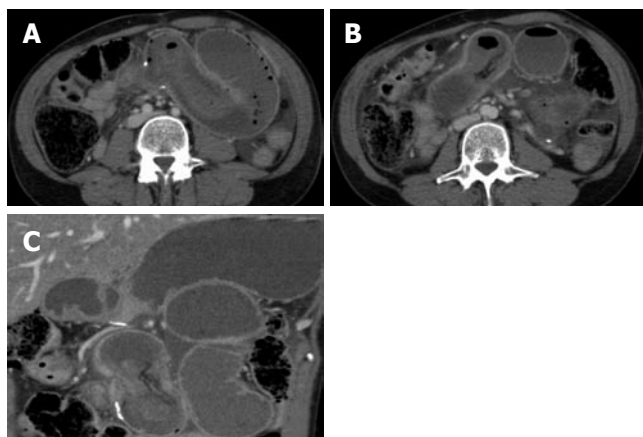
Axial (A and B) and coronal (C) CT images of the abdomen following intravenous contrast administration, which show large dilated loops of small bowel proximal to the intussusception. The intussuscepted bowel entered the more distal jejunum via the jejunal anastomotic site, which is evident due to the presence of surgical clips.
